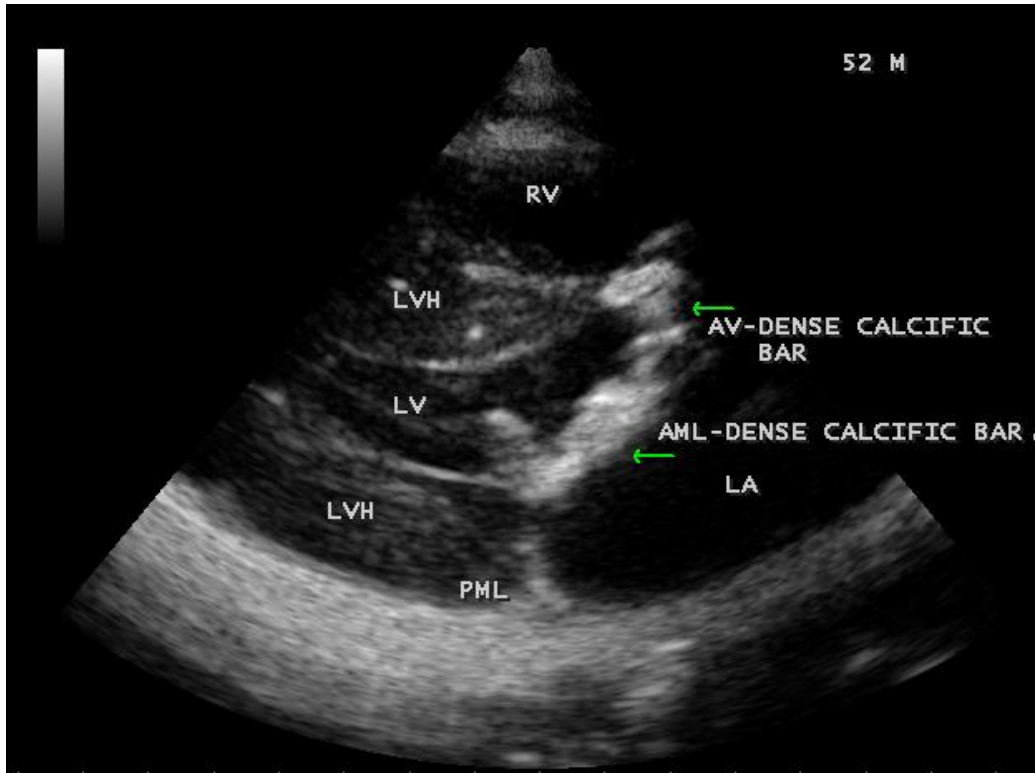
Parasternal long axis view showing the anterior mitral leaflet as a dense calcific bar with opening of the stenotic mitral valve in a 52-year old male.
